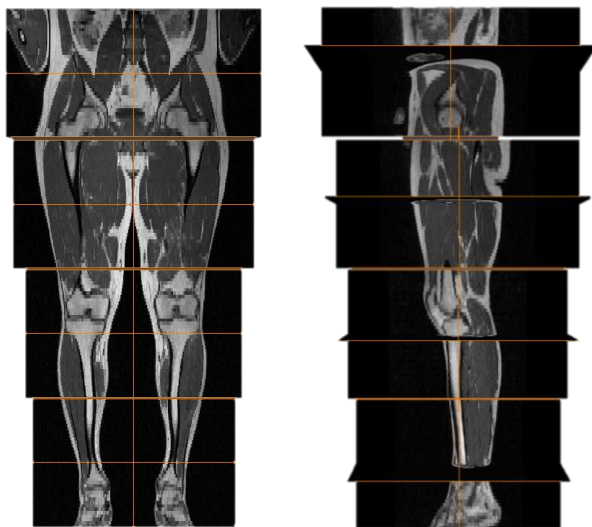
The MRI of the lower extremity from frontal and sagittal views
